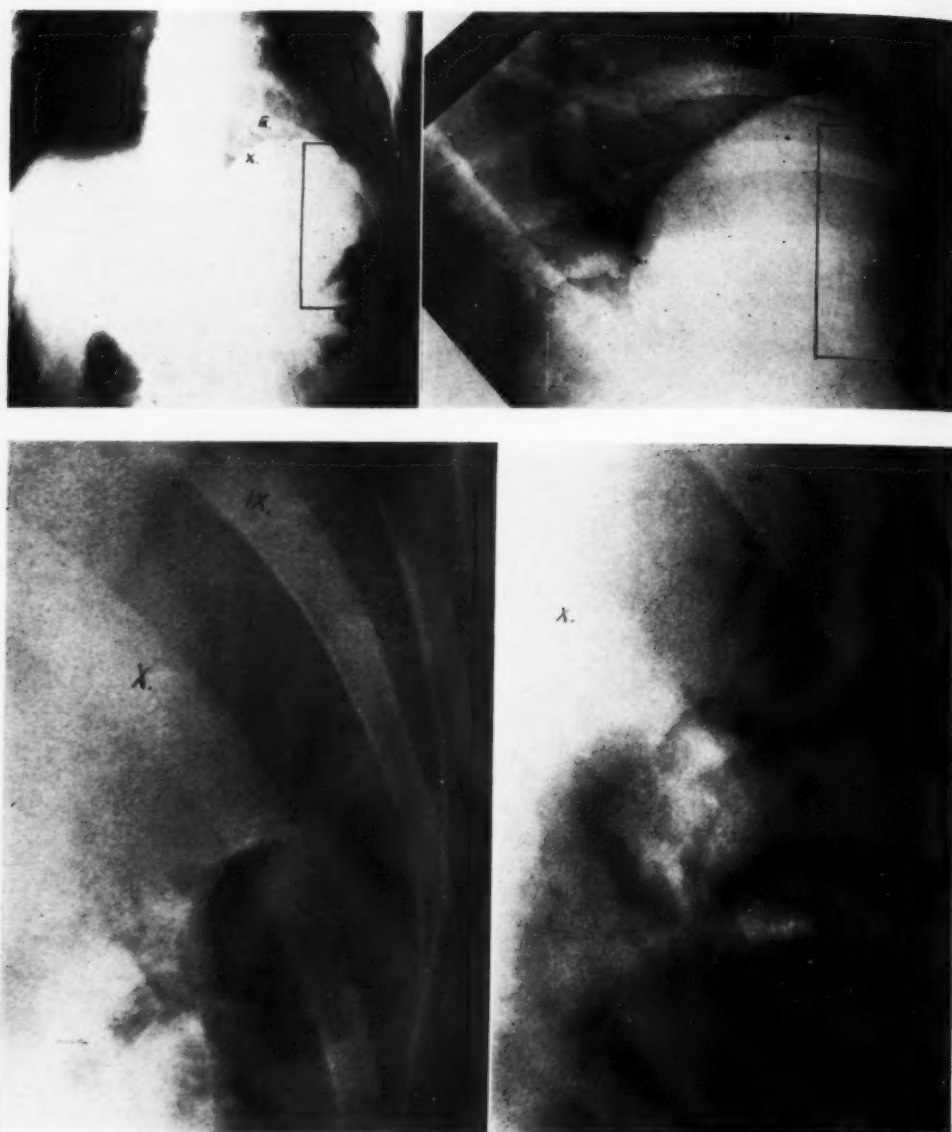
Anteroposterior and oblique roentgenograms (with magnifications below) made Feb. 20, 1943.
